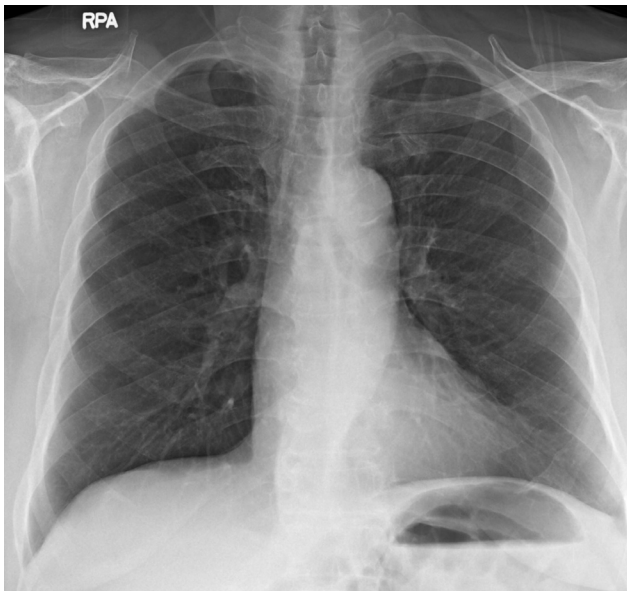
Initial chest radiograph showing no abnormalities.
